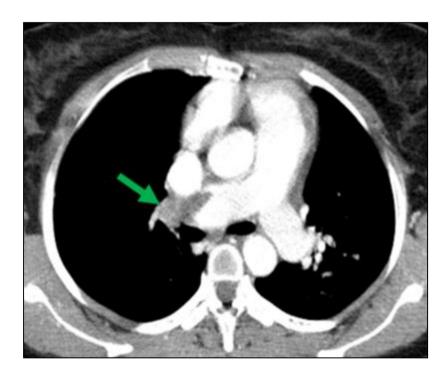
Axial CT angio section of the thorax in mediastinal window. There is an embolus in the trunk of the right pulmonary artery (green arrow)
